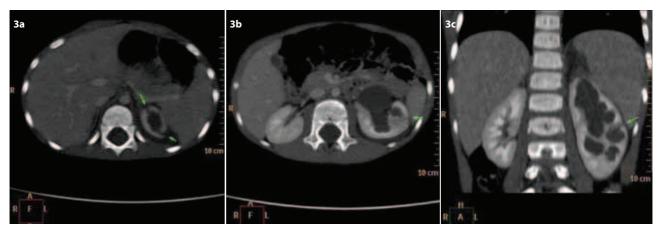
Contrast enhanced computed tomography (CECT) of upper abdomen: a. Two lacerations of left kidney upper pole, extending to the collecting system (arrows). Perinephric collection is noted; b. and c. contusion of upper pole (arrow). Pelvicalyceal dilatation and thinned cortex are also observed.
